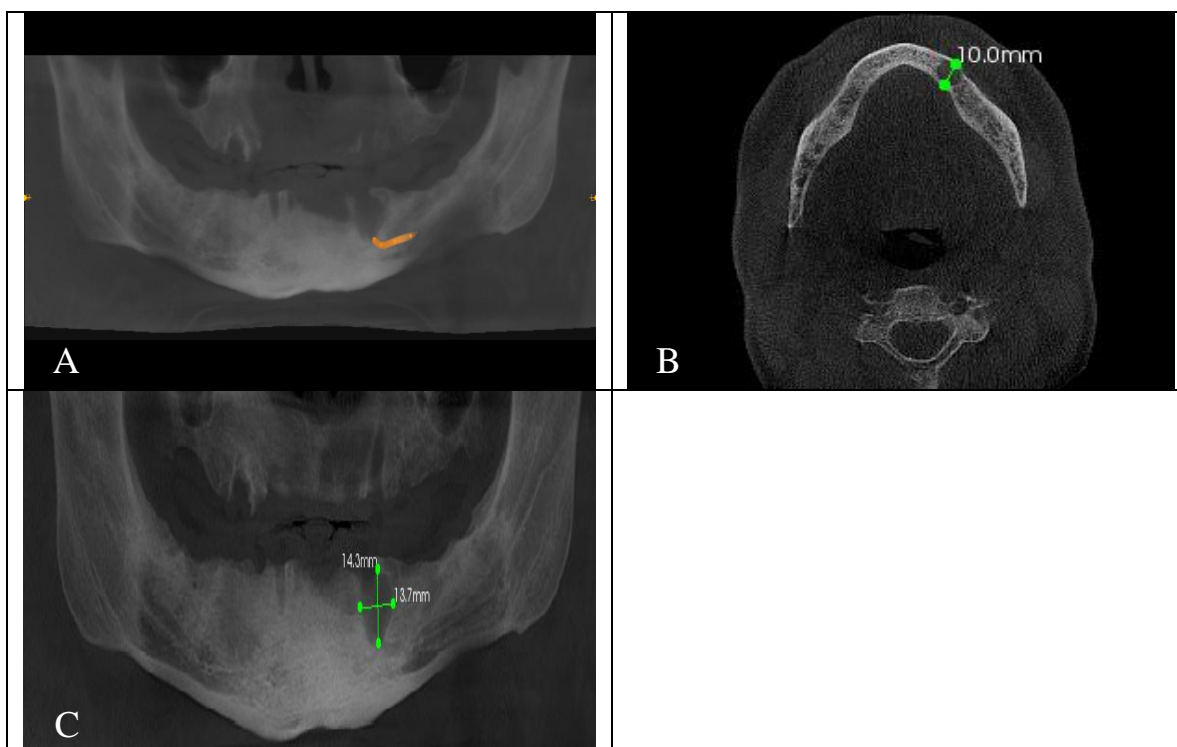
CBCT radiograph: (A) CBCT show the direct association between the mental nerve and the lesion. (B and C) CBCT show the size of the lesion
